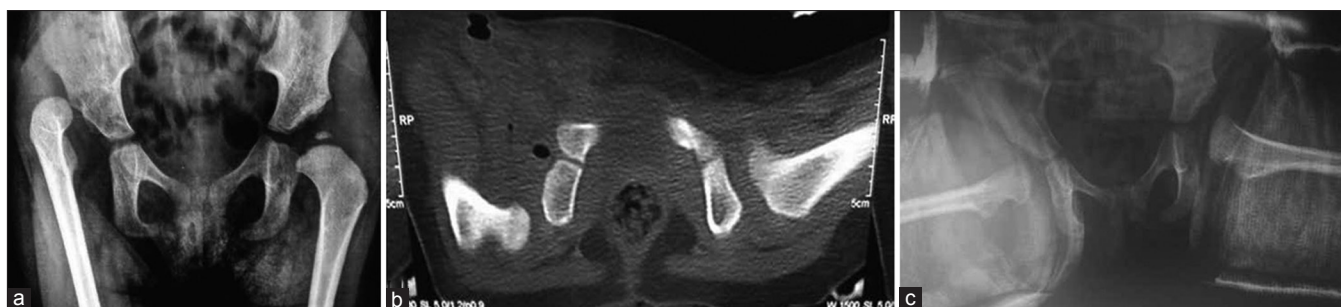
(a) X-ray pelvis with both hip joints anteroposterior view in a 15-month-old infant showing unilateral right developmental dysplasia of the hip with absence of ossific nucleus at the time of closed reduction (b) Computed tomography scan in spica showing that the hip is dislocated. The child was treated with adductor tenotomy and spica cast application (c) X-ray frog leg lateral view of same child who underwent remanipulation showing hip is well reduced
